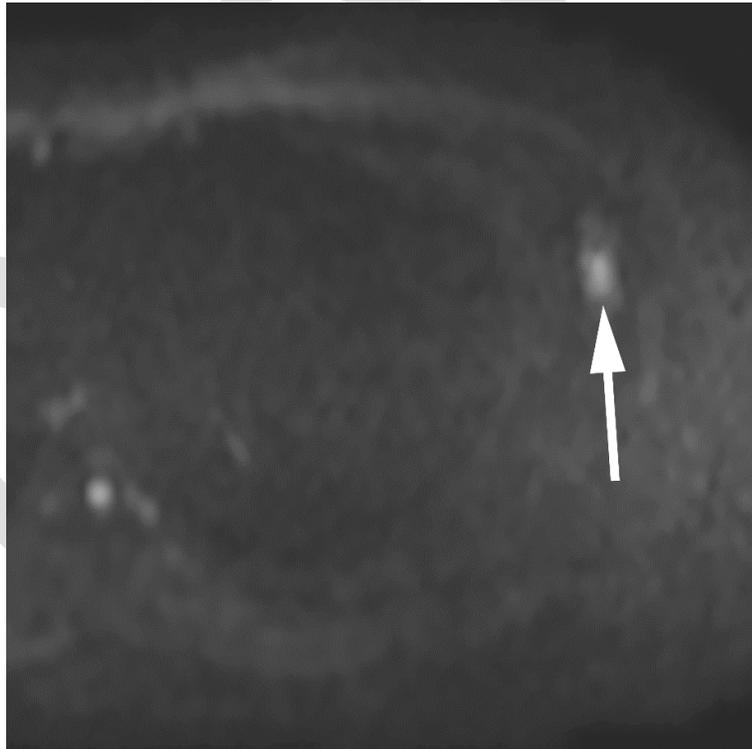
Images in a 50-year-old man 10 days after COVID-19 vaccination. (A, B) Axial T2-weighted image (A) and diffusion-weighted image (DWI) (B) obtained at post-vaccination MRI demonstrate an enlarged lymph node (arrows) in the left axilla ipsilateral to the vaccinated site. (C, D) Axial T2-weighted image (C) and DWI (D) obtained at pre-vaccination MRI demonstrate the corresponding lymph node (arrowheads). The enlarged lymph node on post-vaccination MRI scans is obviously larger than the corresponding lymph node on pre-vaccination MRI scans. The enlarged lymph node on the T2-weighted image at post-vaccination MRI demonstrates a higher signal intensity than the corresponding lymph node on T2-weighted image at pre-vaccination MRI.
